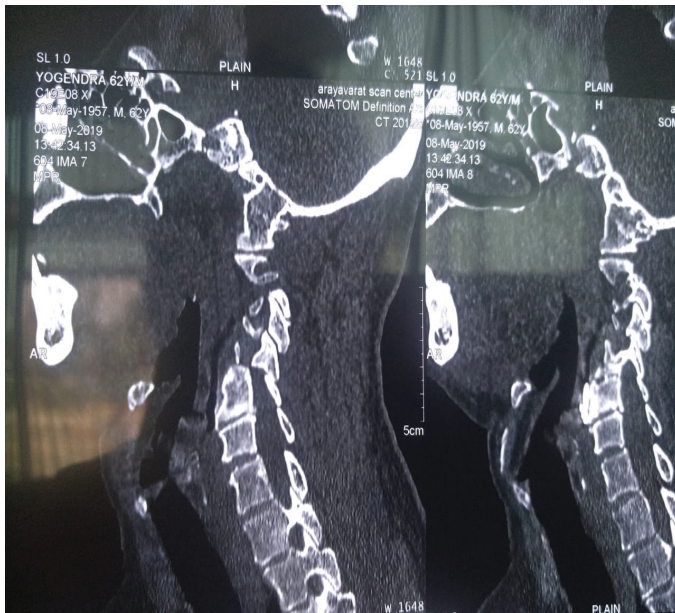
CT scan of C-spine, confirming fistula track communicating to hypopharynx
